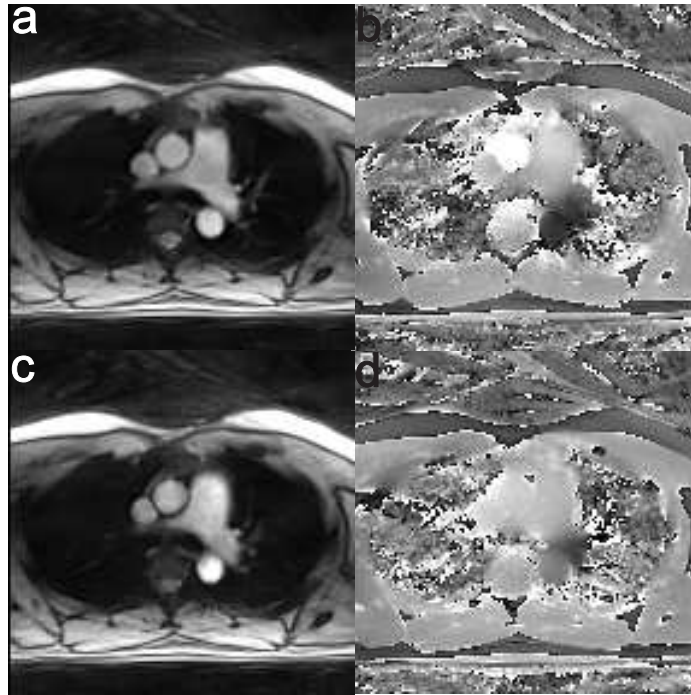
Transverse view of the human heart at the region of ascending aorta: (a, c) magnitude images and (b, d) phase-contrast maps obtained (a, b) with and (c, d) without velocity encoding using real-time dual-echo PC MRI.
